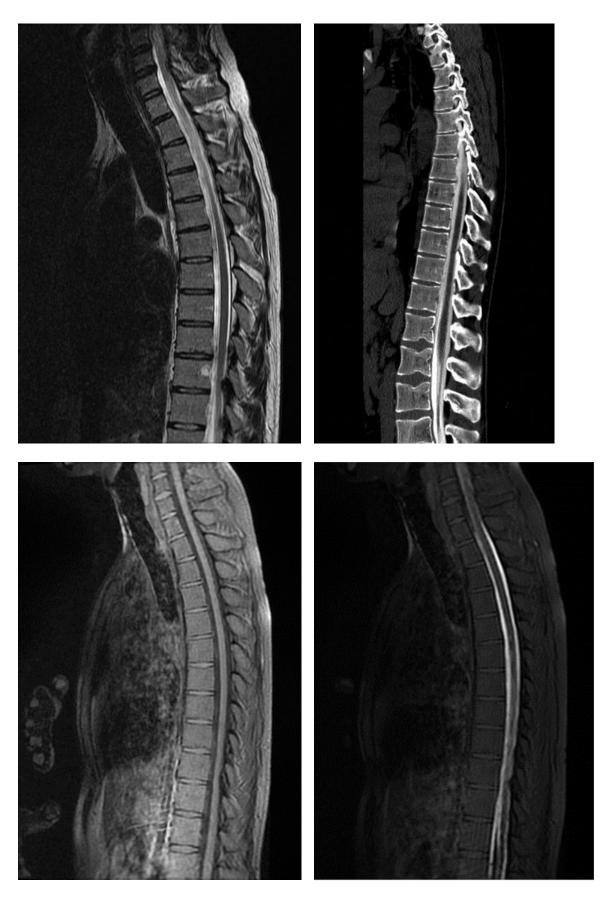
T2-weighted MRI (upper left); CT myelography (upper right); unenhanced T1-weighted MRI (lower left); T1-weighted MRI with intrathecal Gd-DTPA (lower right). The fluid collection is not apparent in sagittal images.
